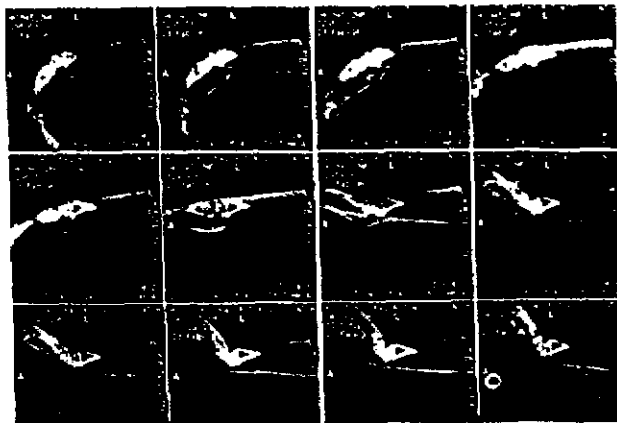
Midsagittal computed tomographic image through metacarpal, capitate, lunate, radius. The wrists were moved slowly and from full flexion to full extension. Twelve images were obtained for each location from flexion to extension.
